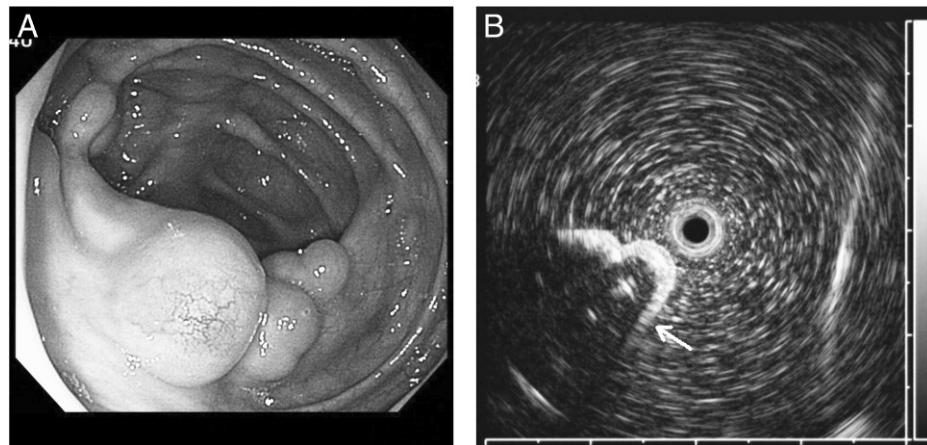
Colonoscopy. (A) Multiple soft hemispheric submucosal tumor-like protrusions are observed. (B) Endoscopic ultrasonography showed a hypoechoic lesion with an acoustic shadow in the submucosa.
